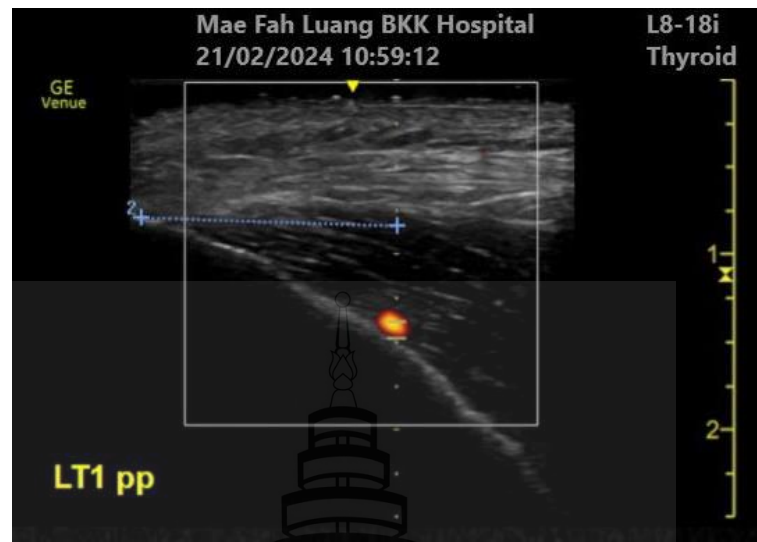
The ultrasound detection found the deep temporal artery at the Above the periosteum
